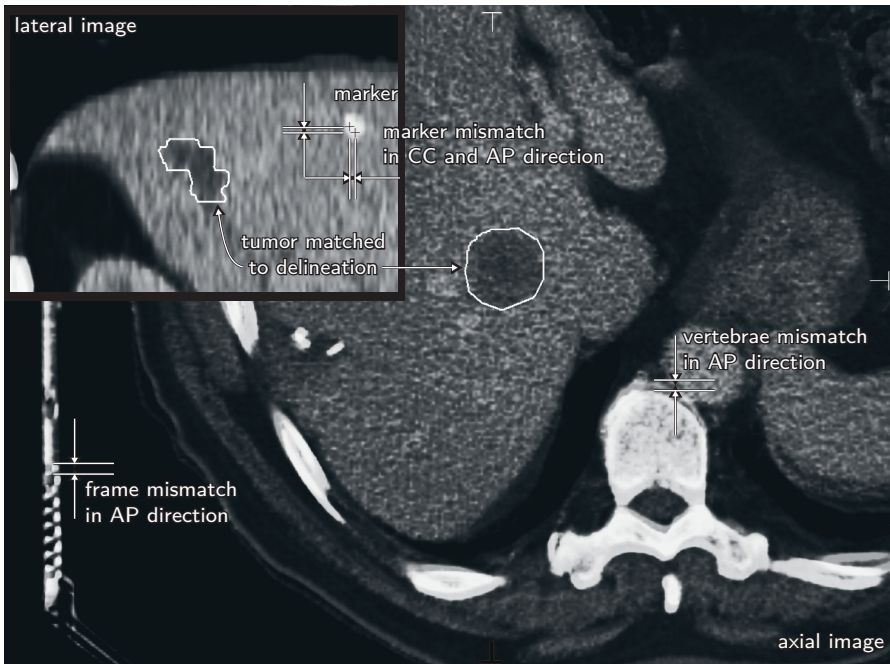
A planning CT (gray scale) and a fraction CT (superimposed) after registration of the tumour. Dashed arrow in lateral image: tumour-marker distance, dotted arrow: tumour-diaphragm distance (measured in 3D). Example of mismatches of the stereotactic body frame, vertebra and implanted marker after tumour registration are indicated.
